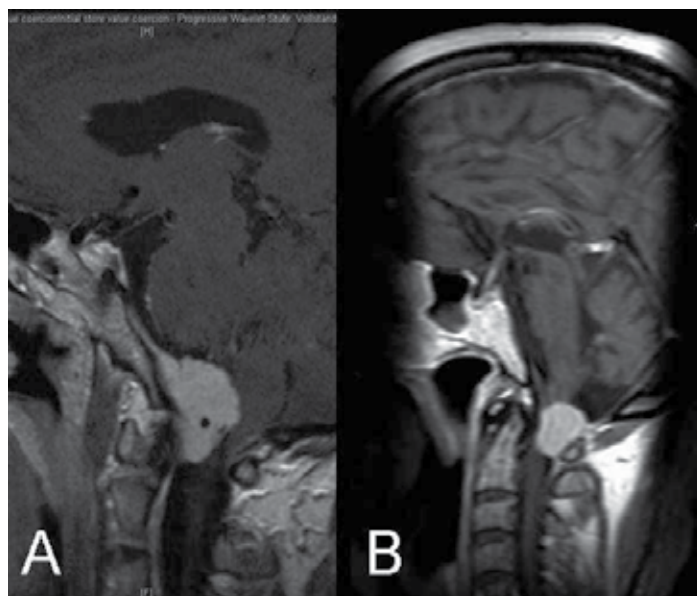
Magnetic resonance tomography (coronar, T1-weighted, after application of gadolinium), showing A: a ventro-lateral and B: a dorso-lateral foramen magnum meningioma.
